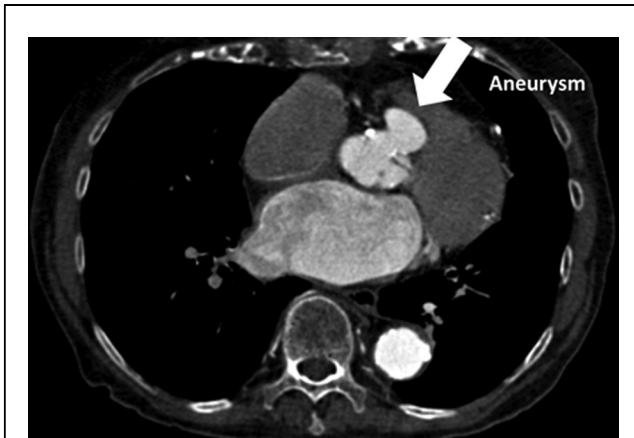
Short-Axis View Obtained by Computed Tomography
